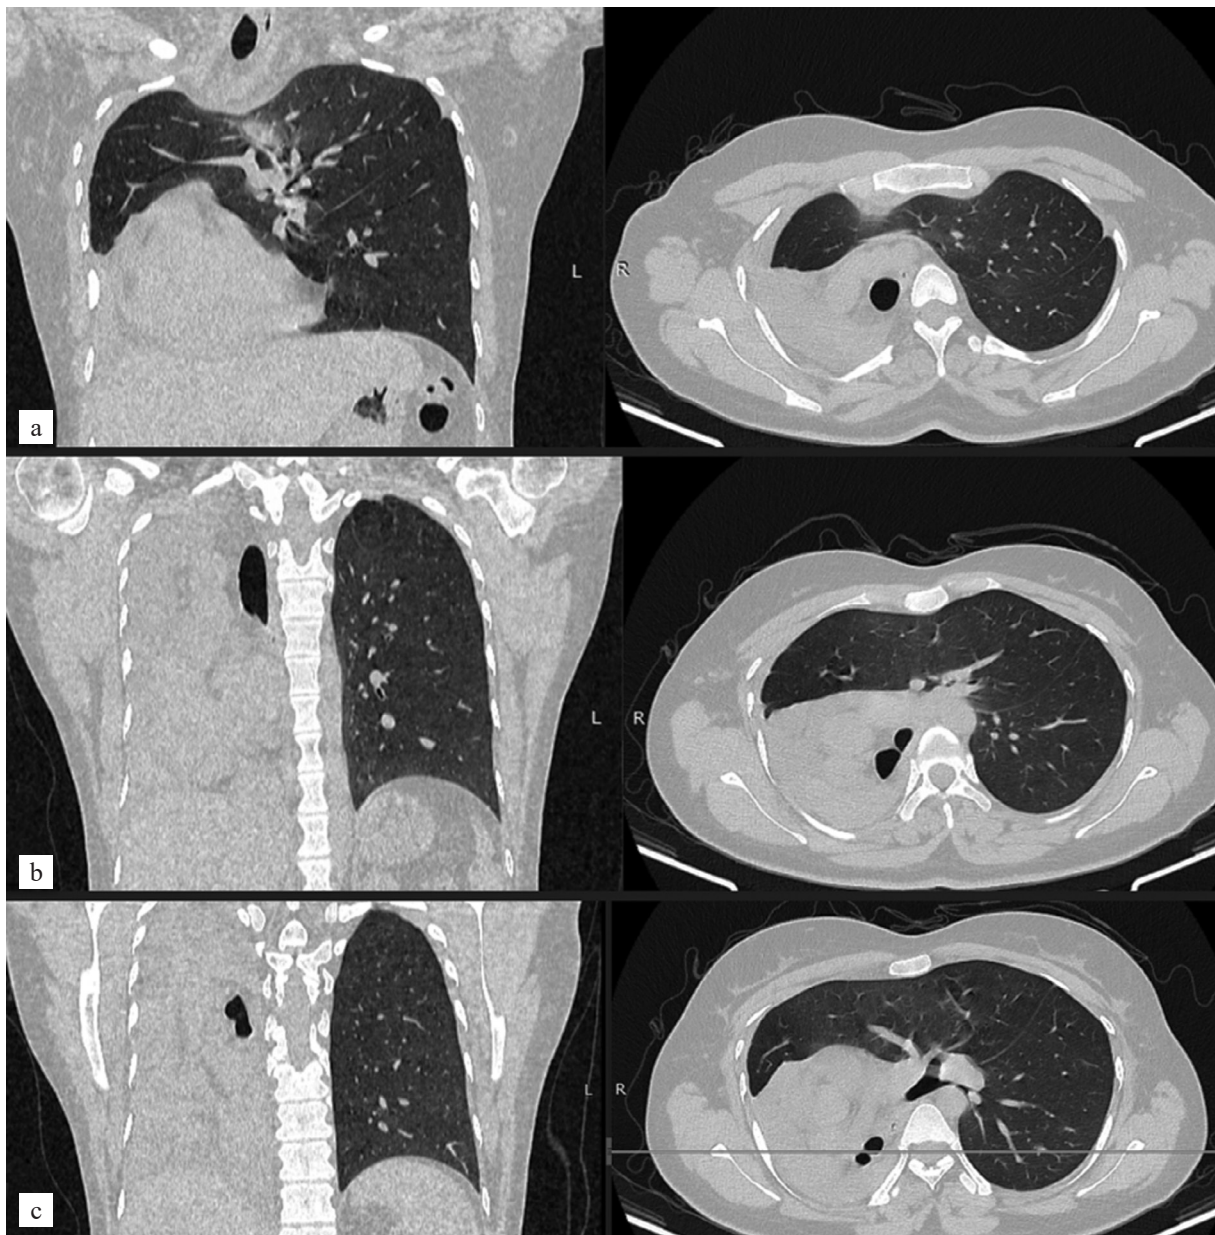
Computed tomography findings 1 year after endoscopic treatment: a, 3rd thoracic vertebra; b, 5th thoracic vertebra (tracheal bifurcation); c, 7th thoracic vertebra (site of right main bronchus atresia)
